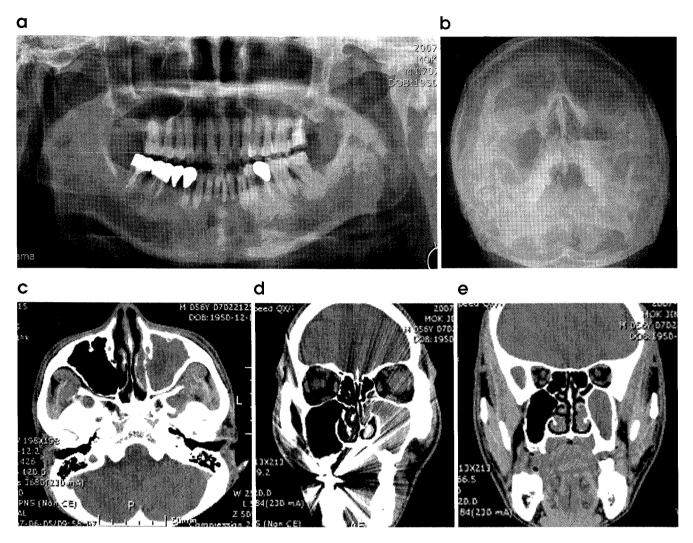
(a) Fluid in left maxillary sinus showing as lower radiopacity in panoramic view; (b) Fluid level of left maxillary sinus best showing in Waters' view; (c), (d), (e) Fluid in left maxillary sinus appear as overall radiopacity in CT with patient supine position.
